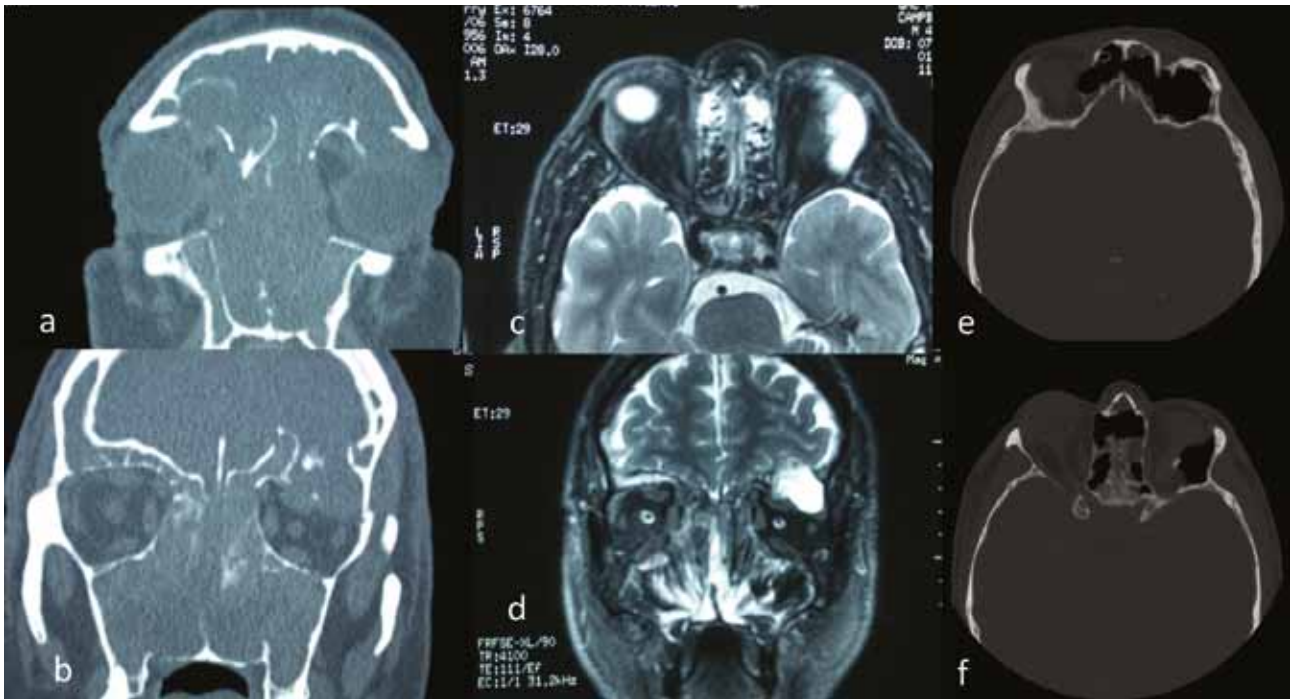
Nasal polyposis with left lateral orbital mucocele. a-b pre-op Coronal CT scans, b-c pre-op MRI scan, e-f 24 months post-op CT scans
